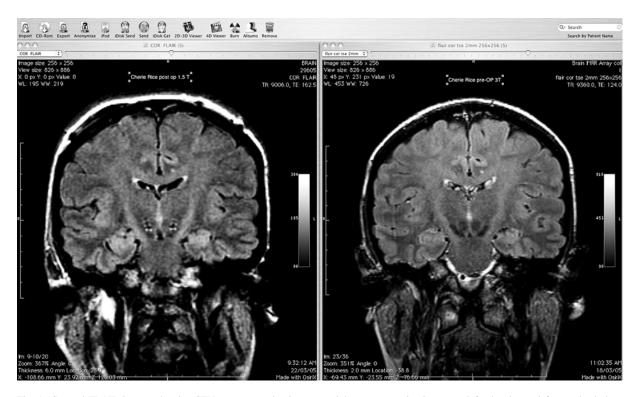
Coronal FLAIR images showing STN - pre-operative image on right, post-operative image on left, showing satisfactory lead placement
